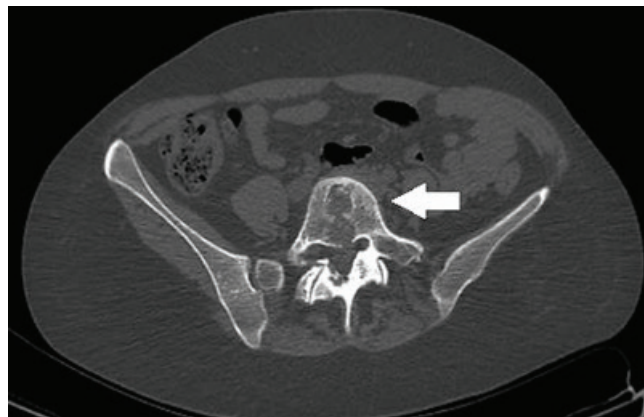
Pelvic CT transversal section revealing osteolytic lesion in S1 (white arrow).
